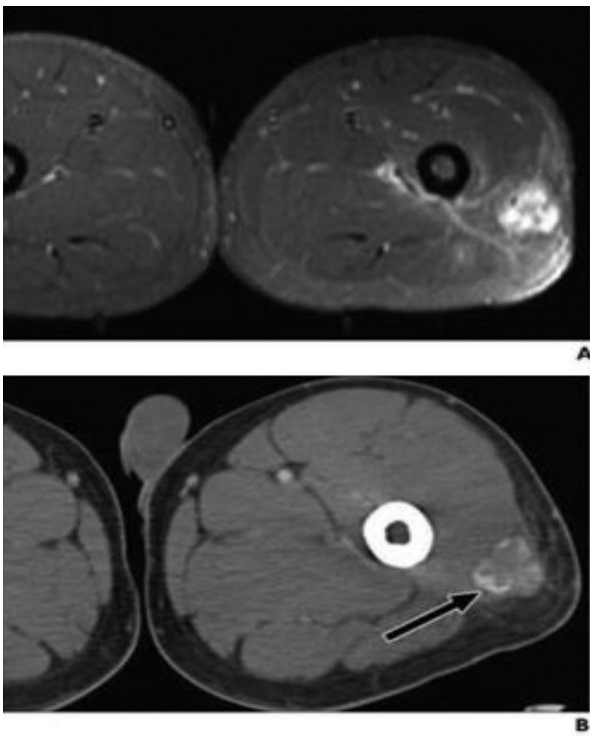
21 year old man presenting with several week long history of painful lesion with progressive increase in size with no history of trauma and no significant radiography finding. (A) MRI shows non specific soft tissue mass in posterolateral thigh with diffuse enhancement and surrounding edema as seen on fat saturated axial T1 weighted image obtained after administration of gadolinium contrast agent. (B) Follow up CT suggests final diagnosis of heterotopic ossification (myositis ossificans) by revealing characteristic peripheral zone of ossification.
